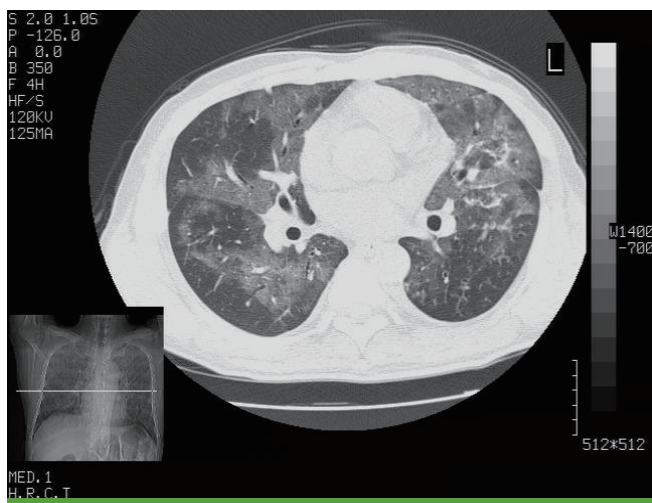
The chest CT scan at the first admission shows ill defined ground glass opacity in both lungs with central and upper lobe predominance.
